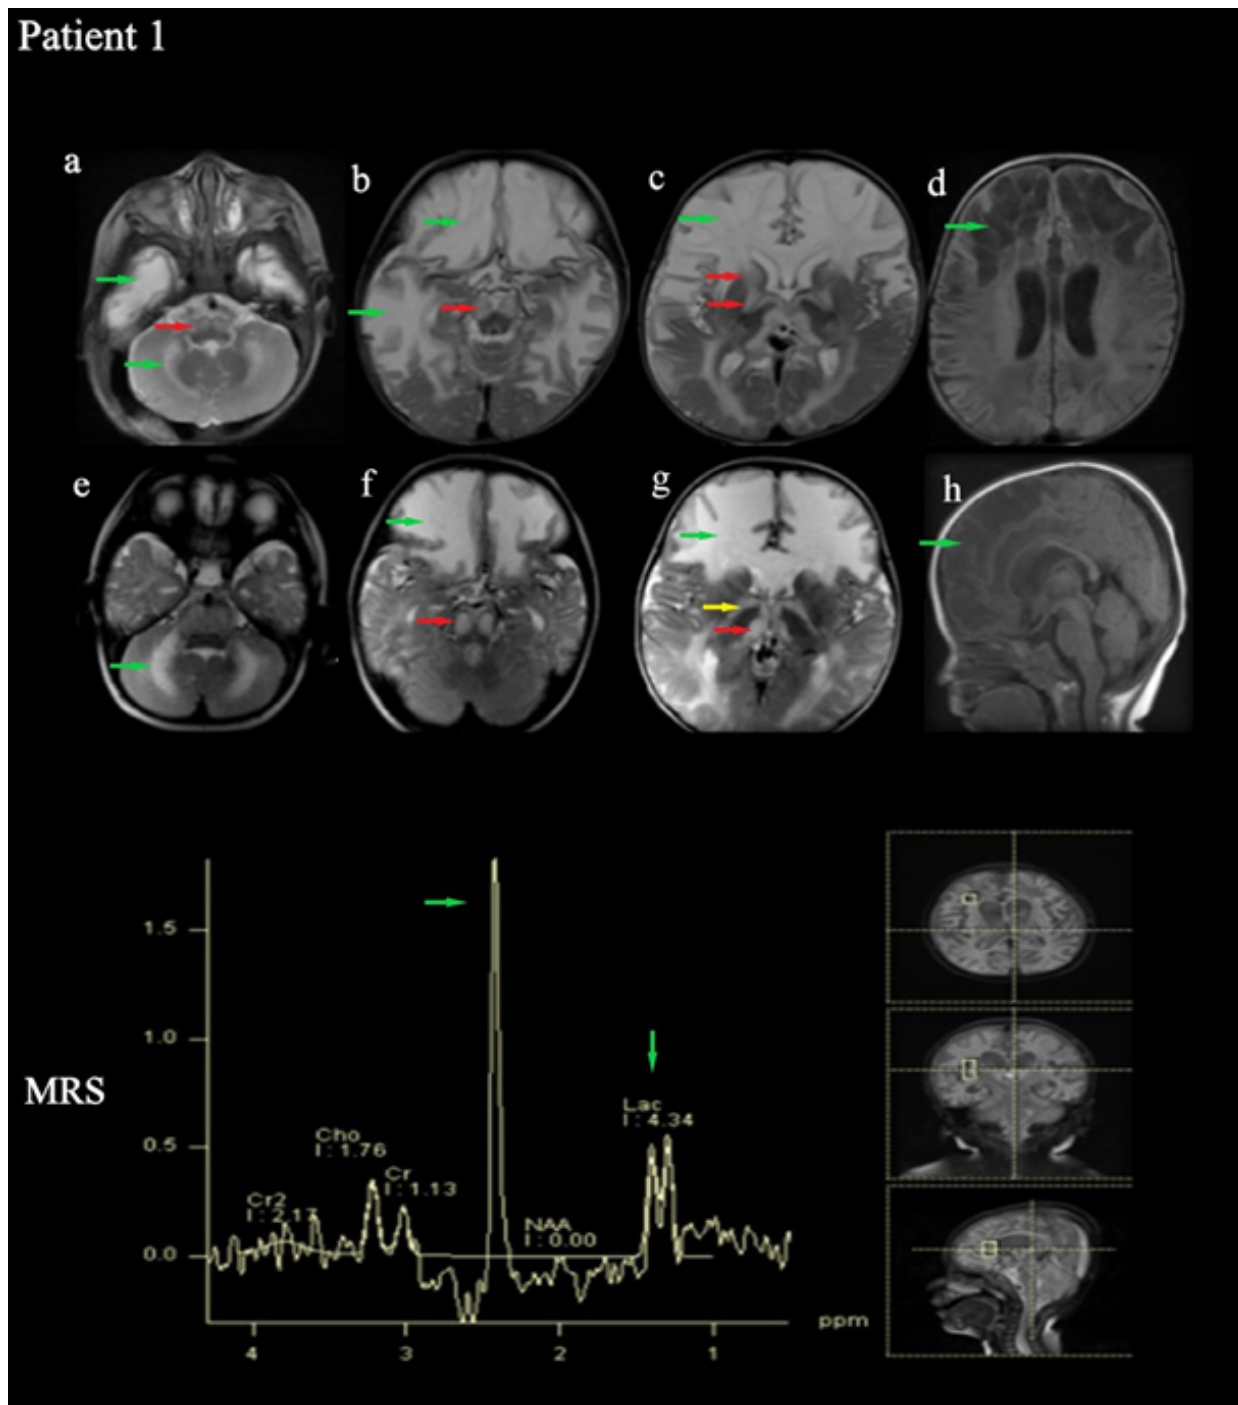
MRI images of Patient 1: Hyperintense T2 signal changes in the frontal, temporal, parietal, occipital cerebral, and cerebellar white matter (green arrows on the a, b, c, e, f, g), corpus striatum (red arrows on the c), thalamus (red arrow on the g), substantia nigra (red arrow on the b), inferior olivary nucleus (red arrow on the a), pyramidal tracts at the level of the pons (red arrow on the f) and posterior limb of the internal capsule (yellow arrow on the g)
